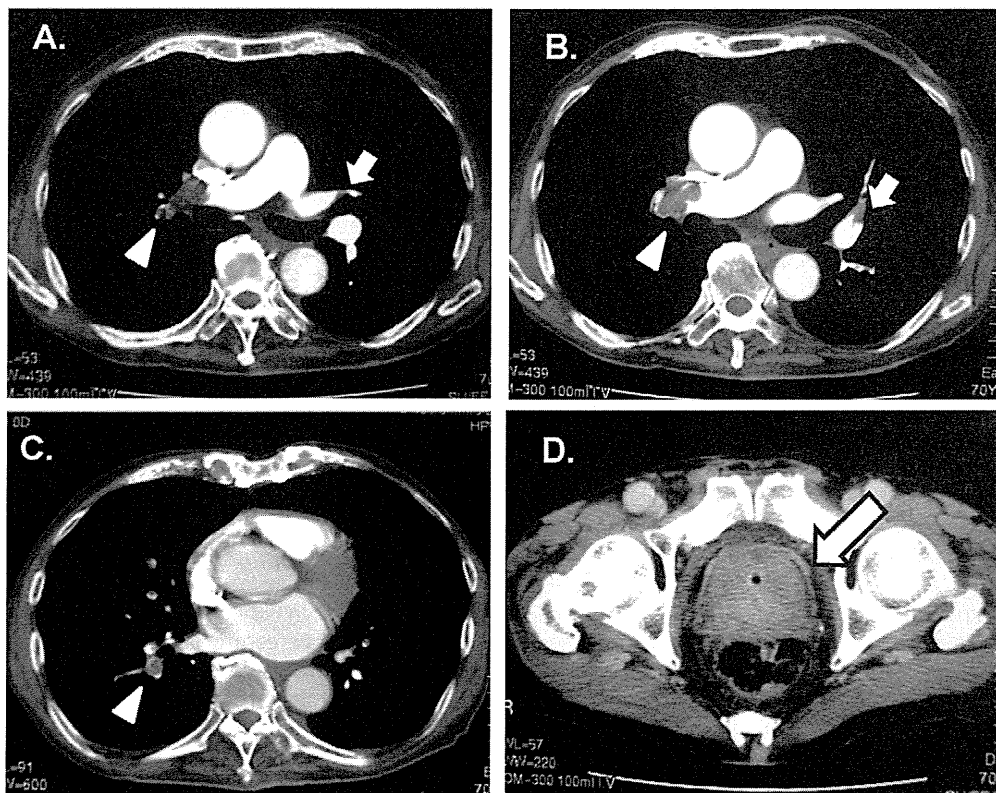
Chest computed tomography (CT) shows clots and disturbed blood flow in right distal pulmonary artery and left segmental branch (A–C). Clots are shown by arrowheads. Pelvic CT shows enlarged prostate (D, arrow).
